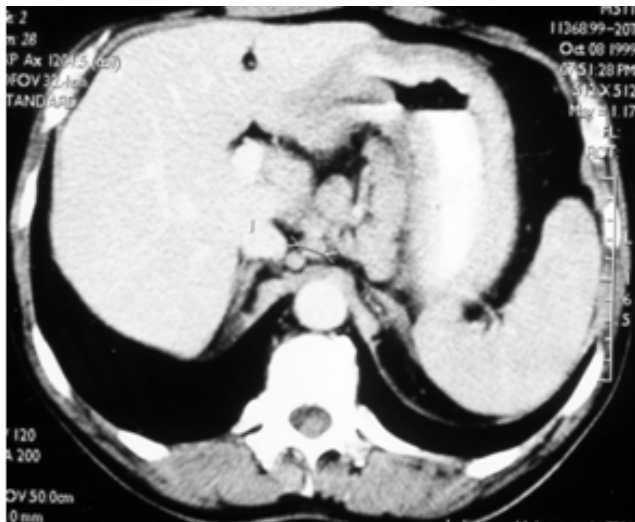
An image of thoraco-abdominal CT scan, showing a thickened gastric walls and lymphadenopathy in celiac trunk.
